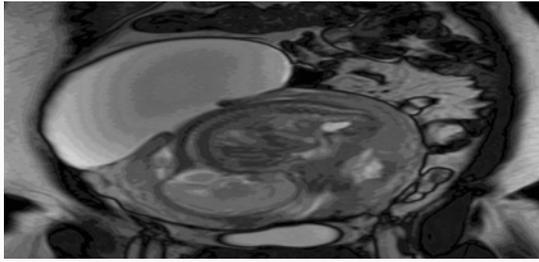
Coronal T2-weighted MRI of the maternal abdomen, showing the fetus in cephalic position and the uterine defect with the intra-abdominal amniotic sac protrusion.
